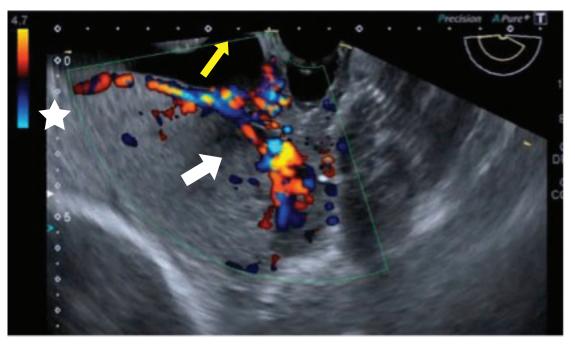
Transabdominal ultrasonographic examination showed retroplacental space hypervascularity (White arrow), placenta is homogenous, low lying (star), bladder (yellow arrow).
